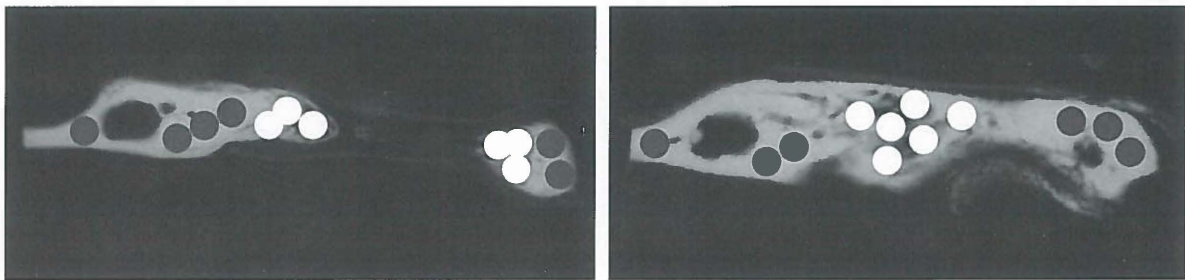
The amount of mineralization of the newly formed bone was determined by dividing the mean grey value of the newly formed bone by the mean grey value of the original mandibular bone (outside the original defect). The mean grey values of the 2 areas were obtained by selecting 12 spots on each radiograph; 6 (white) within the new bone and 6 (grey) within the original mandibular bone. An open (left) and a closed (right) defect are shown.
